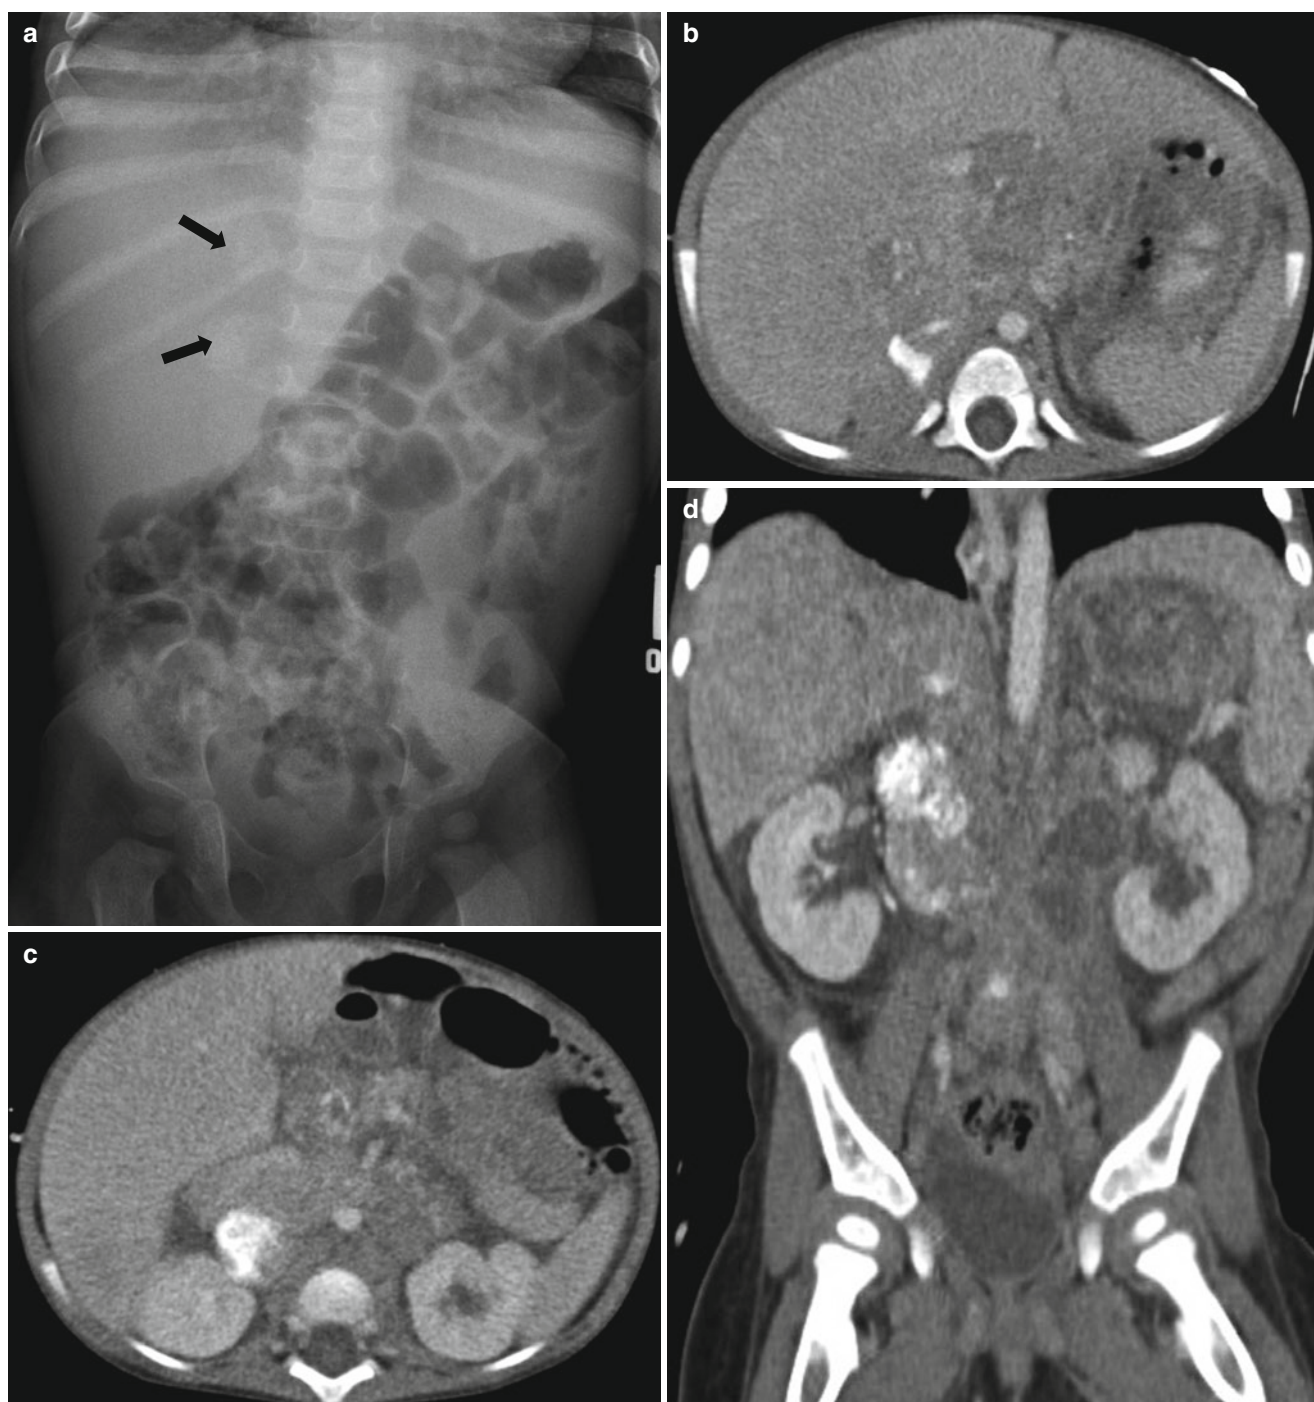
Right adrenal neuroblastoma in a 12-month-old boy. (a) Plain radiograph of the abdomen shows subtle calcifications at right suprarenal and perirenal region (*arrows*). (b and c) Contrast-enhanced CT images in axial (b and c) and coronal (d) planes show a large
